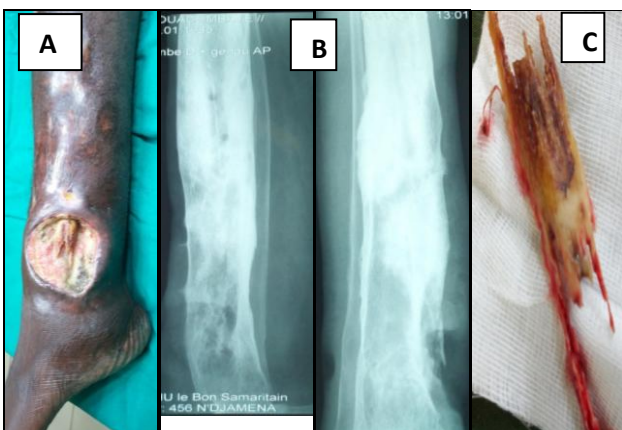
Chronic post-traumatic osteitis (neglected wound) of the tibia seen after about one year in a 19-year-old patient: A1: clinical image on admission; A2: x-ray showing architectural modification of the tibia and sequestra; A3: a necrotic bone fragment after sequestrectomy, curettage and washing
